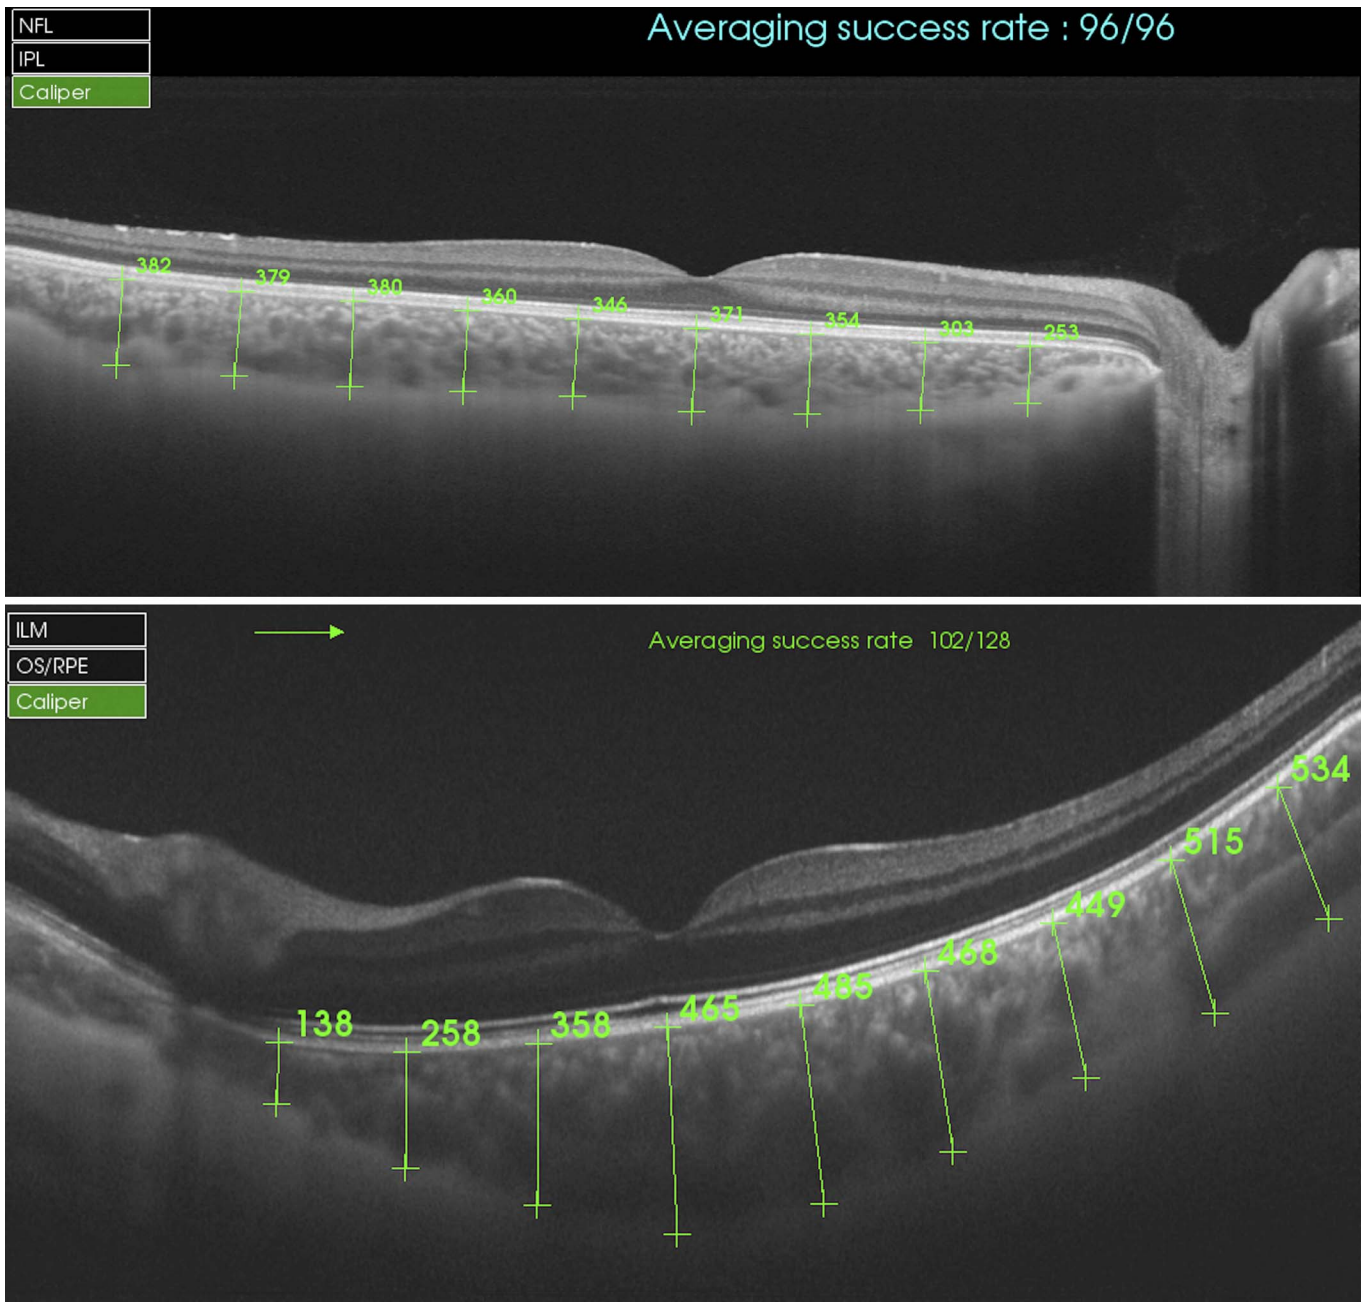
CT was manually measured from the posterior limit of the RPE to the choroid-sclera junction under the fovea in a healthy control (*top*) and in a KC patient (*bottom*). Eight further measurements were performed every 1000 μm : five temporal to the fovea (T1, T2, T3, T4, and T5) and three more nasal to the fovea (N1, N2, and N3).
